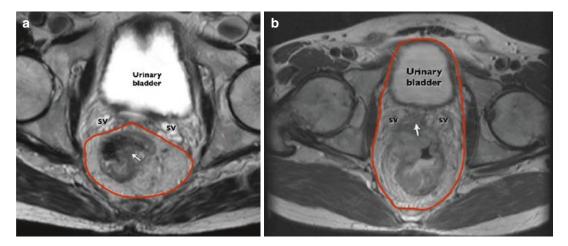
(a) Magnetic resonance imaging demonstrates the standard total mesorectal excision (TME) plane. The red line shows the standard TME plane around the fascia propia of the rectum. The arrow points to the tumor that is
